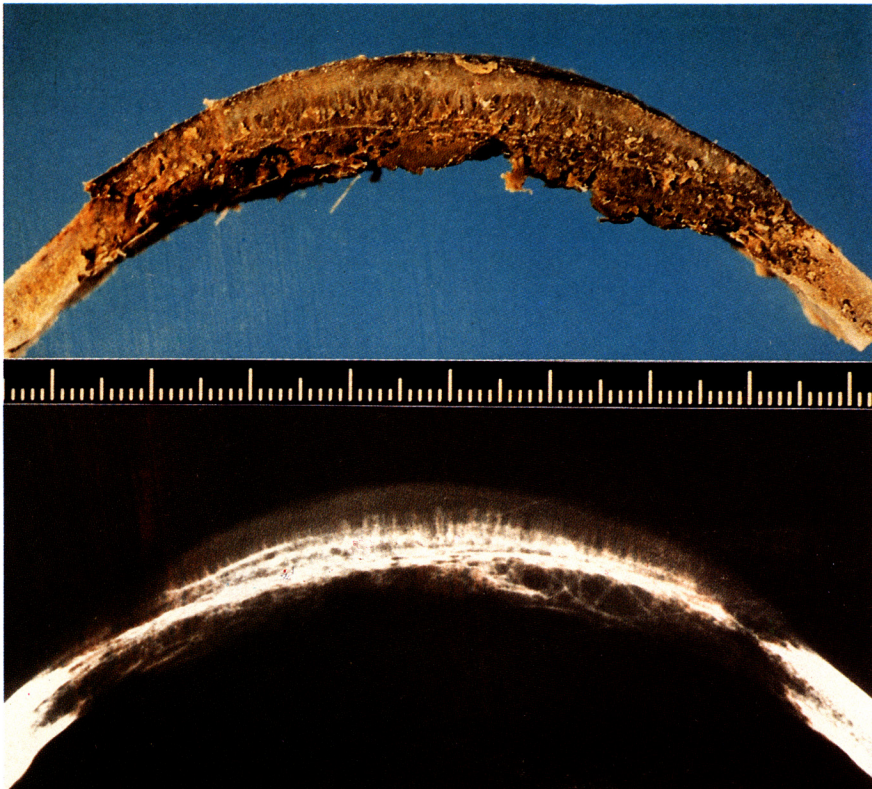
(upper) Cross section of the involved calvarium exhibiting greenish tumor mass with involvement of entire marrow cavity and tables. (lower) Sunburst-like appearance in the x-ray film.
